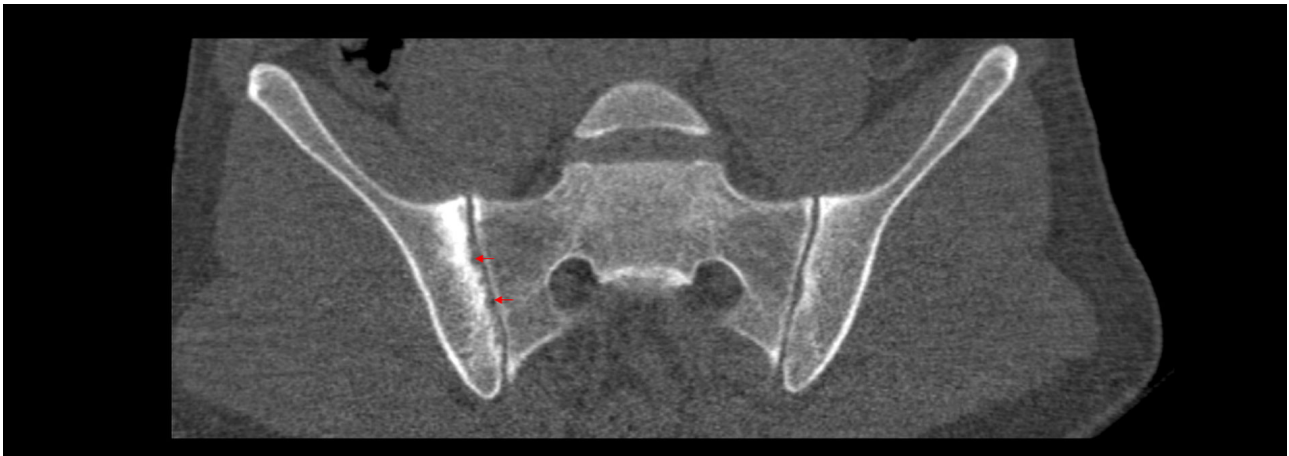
Structural changes on computed tomography (CT) of sacroiliac joints in axial spondyloarthritis (axSpA). The CT scan shows extensive erosive changes (arrows) and sclerosis in the right sacroiliac joint in a 37-year-old patient with axSpA
